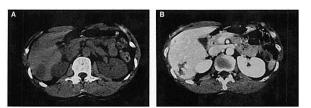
A: CT scan of the liver without the use of contrast agents. Low-density lesions indicate the presence of colon cancer metastases.
